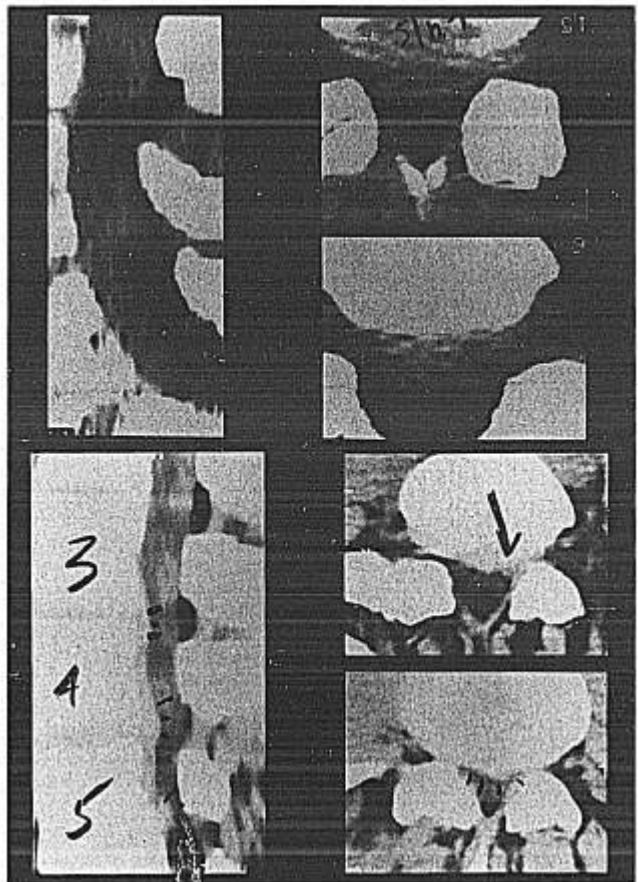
Examples of CT scans in two patients with chronic back pain and very similar symptoms and clinical examinations (From Halde-man et al, Spine 13:345, 1988).
